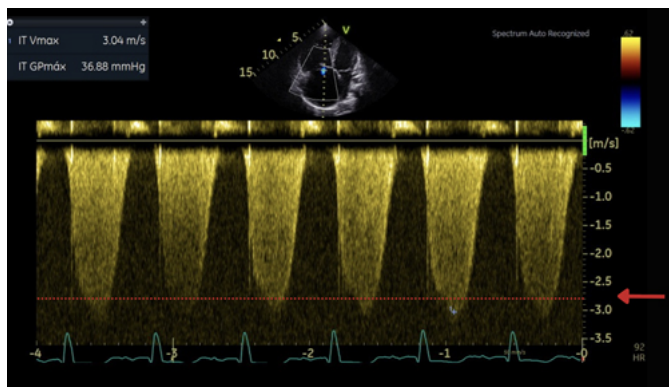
Echocardiogram with pulmonary hypertension. Increased systolic peak tricuspid regurgitant velocity (3.04 m/s). This velocity, along with an estimated PASP of ~40 mmHg, is consistent with pulmonary hypertension. For reference, a systolic peak tricuspid regurgitant velocity >2.8 m/s (red dotted line) is suggestive of an elevated mPAP (>20 mmHg).
